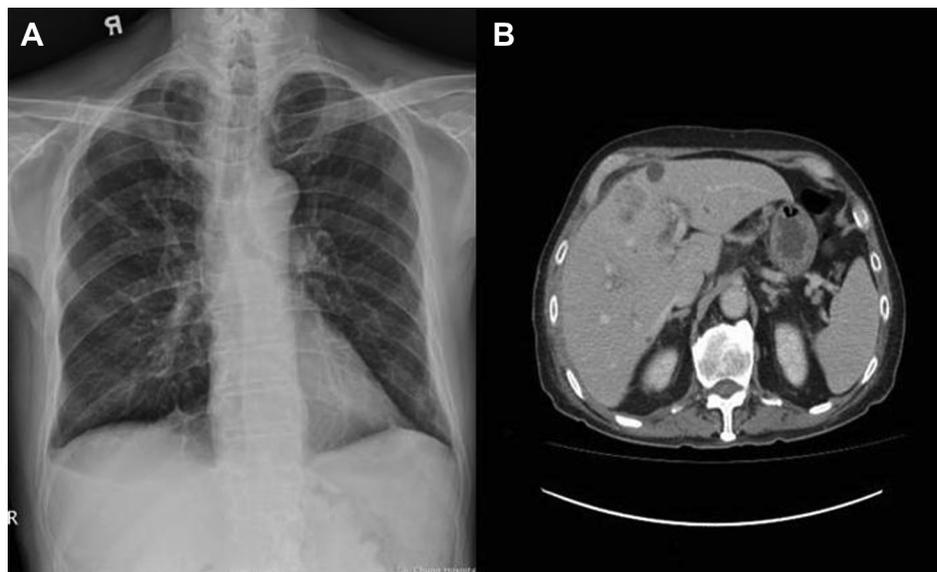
(A) At the first visit to the outpatient department, mild blunting of the right costophrenic angle is noted on the chest X-ray image. (B) A computed tomography scan shows a heterogeneous low-density lesion at the S4 segment and an adjacent cystic lesion.
